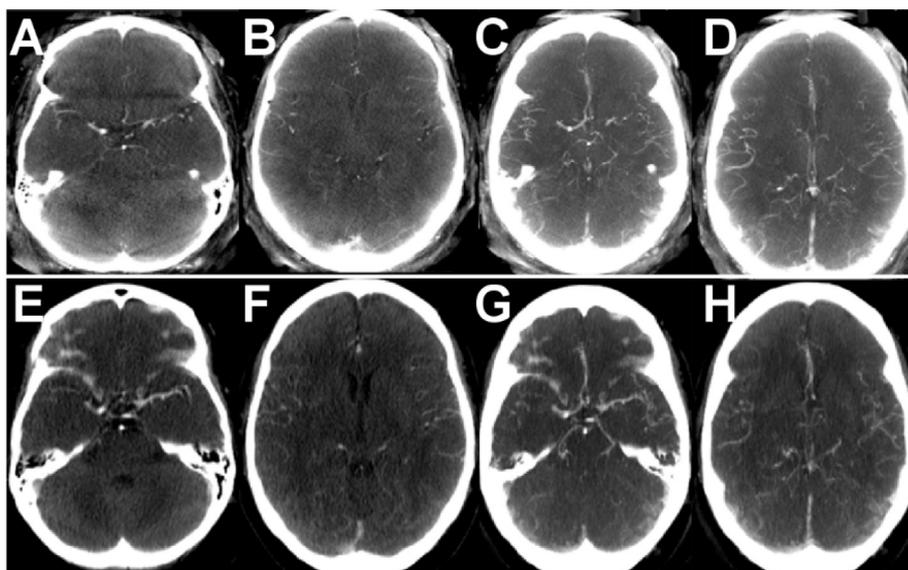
Representative Case Using Collateral Scores. (A–D) FP-CTA of patient with right MCA M1 occlusion and CS of 3 or 4 per all 3 readers. (A, B) Source images. (C, D) MIP reconstruction. (E–H) CTA of same patient demonstrating right MCA M1 occlusion with CS of 2 or 3 per all 3 readers. (E, F) Source images. (G, H) MIP reconstruction.
